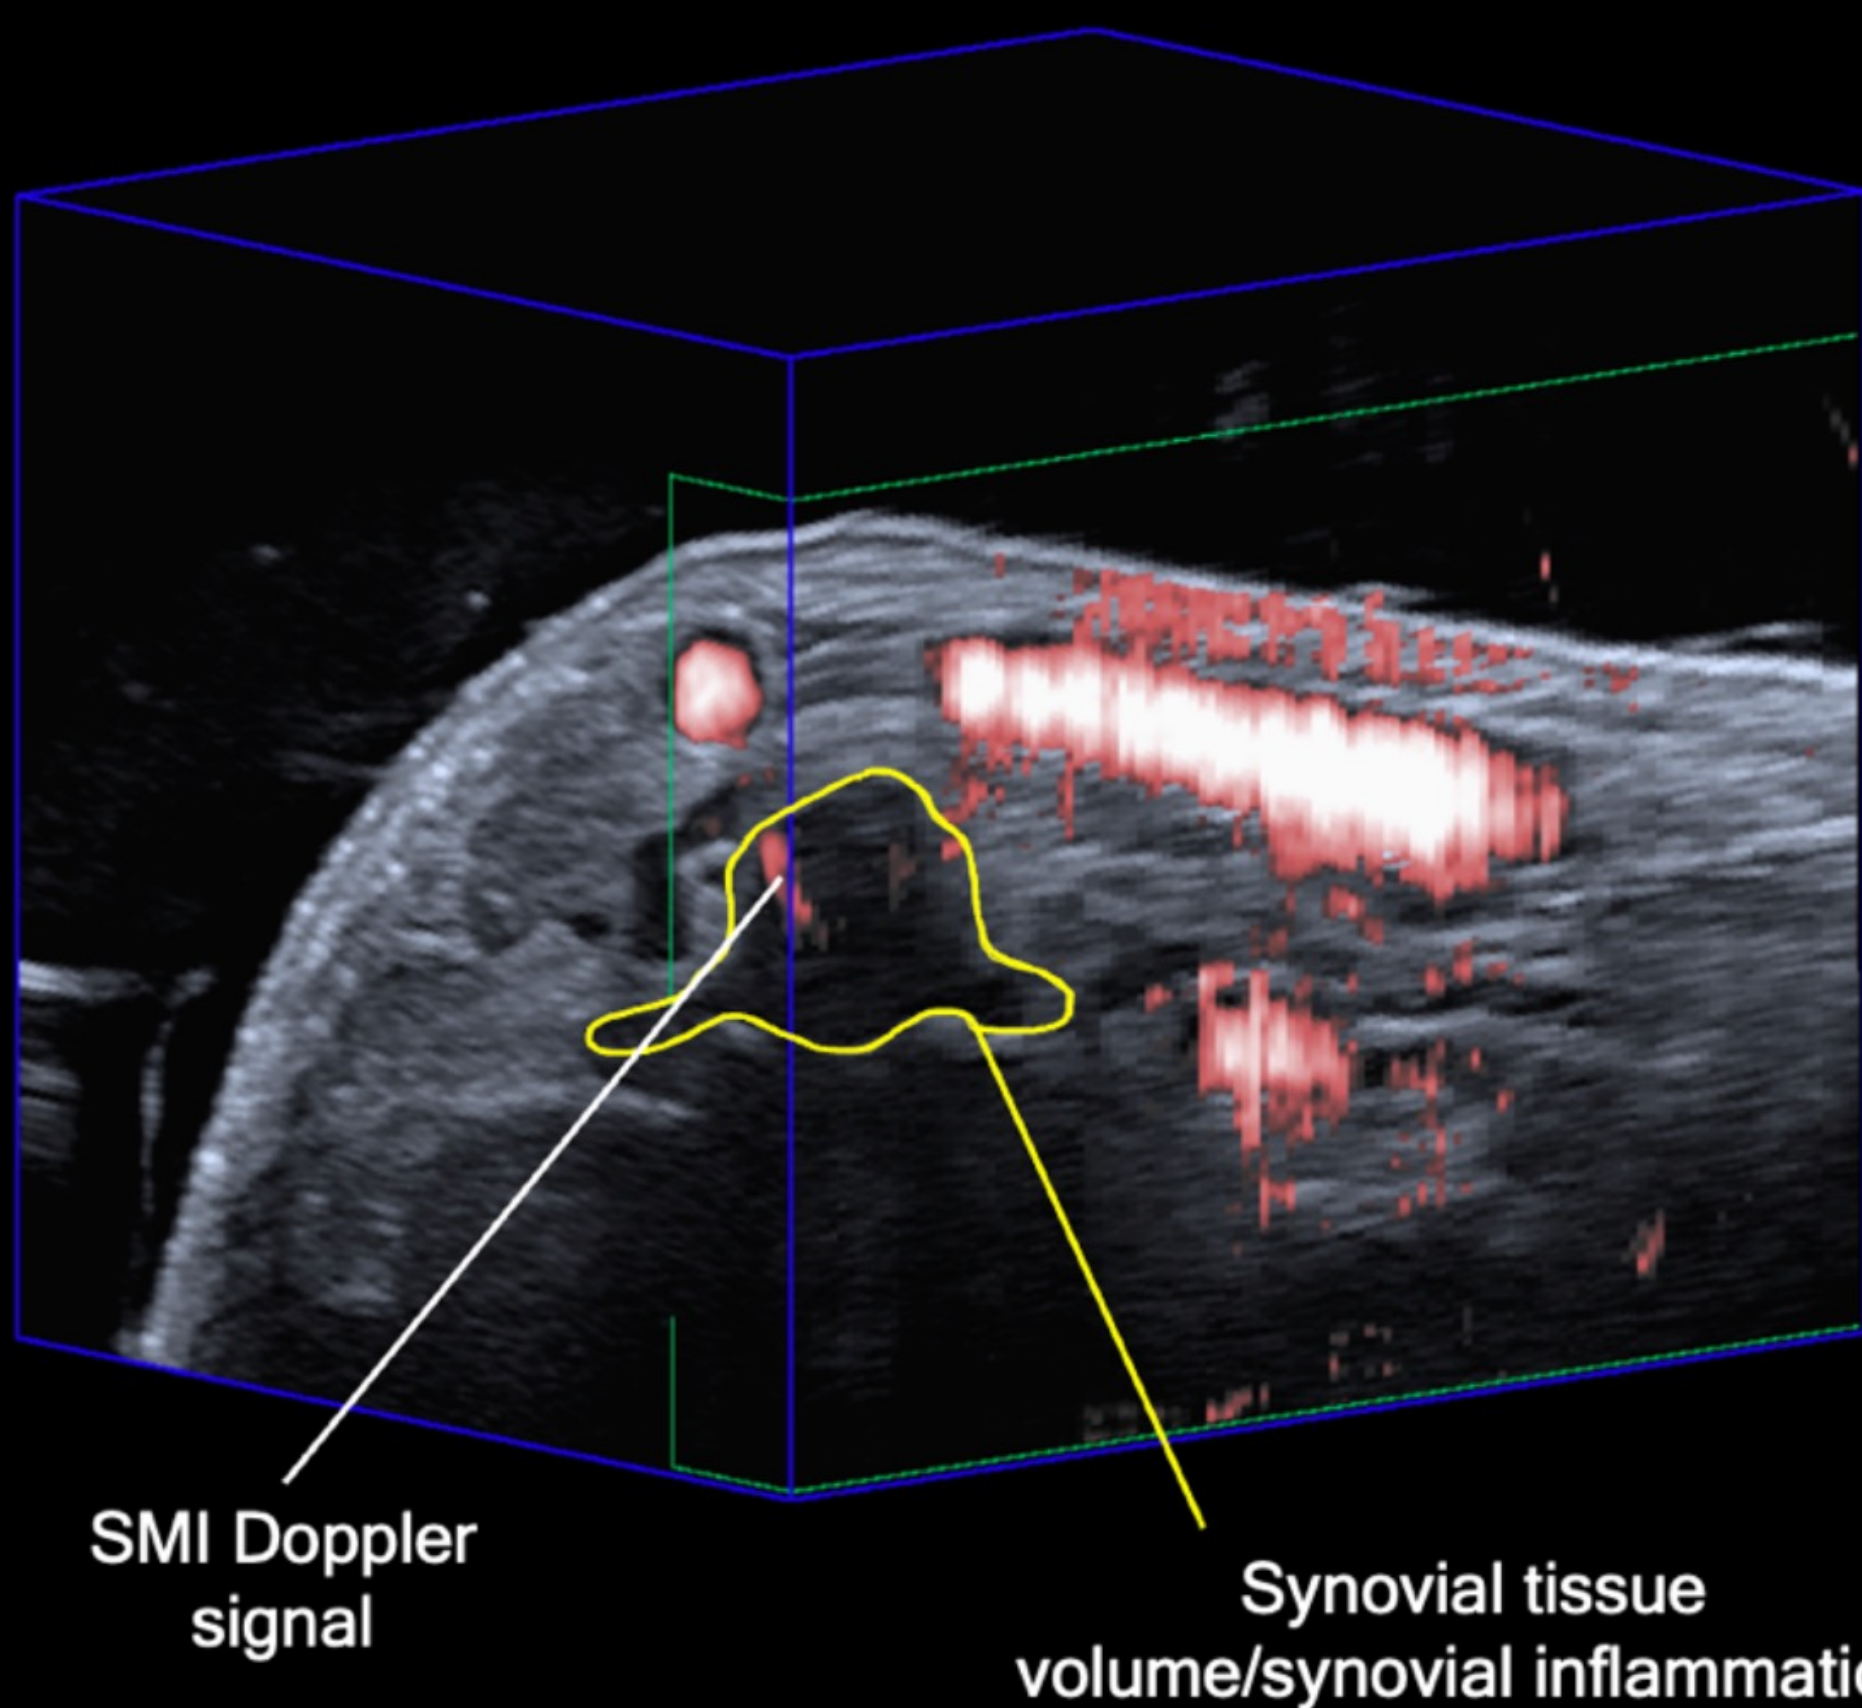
3D US SMI Doppler image of a thumb OA patient. Doppler signals are shown as red voxels in the 3D image and the region of synovial tissue volume is outlined in yellow.
